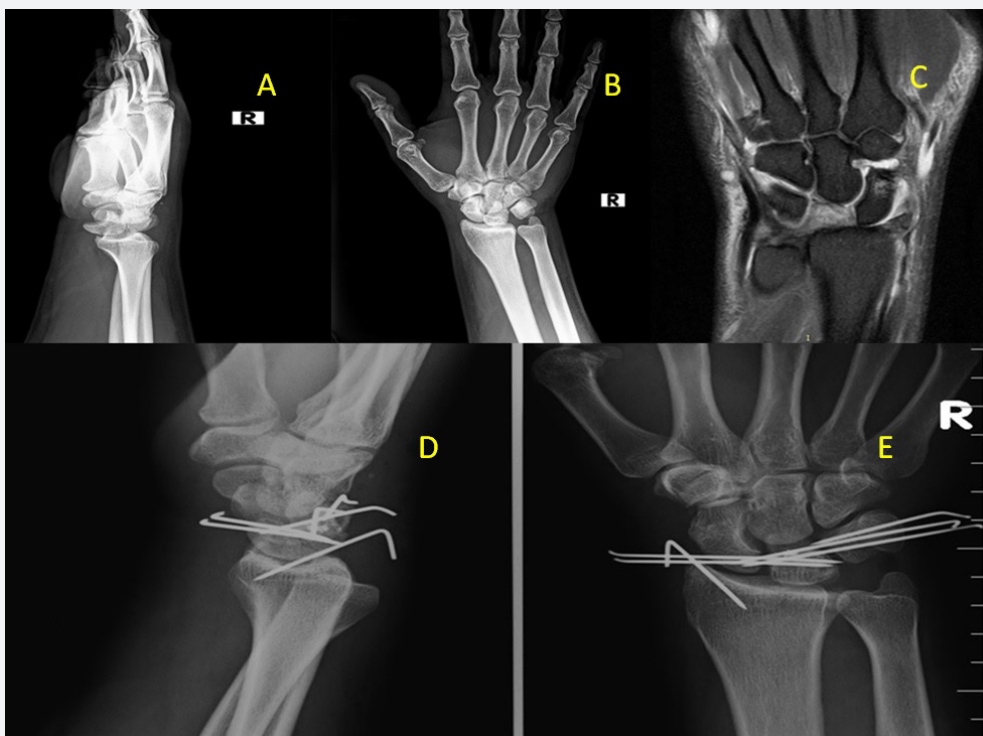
Preoperative and postoperative radiographs of the case with a styloid fracture of the radius. A) Perilunate dislocation and radial styloid process fracture lateral image, B) Anteroposterior image, C) Magnetic resonance image, D) Postoperative lateral image, E) Postoperative anteroposterior image
